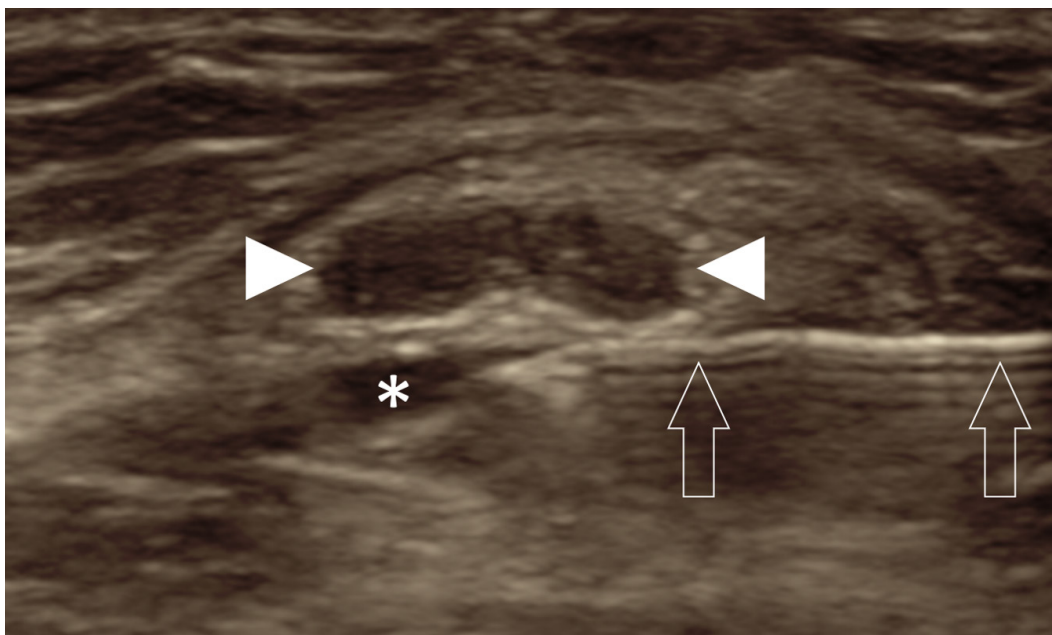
56-year-old male with a history of ulnar nerve transposition and persistent ulnar neuropathy. Ultrasound-guided injection of the transposed ulnar nerve at the level of the medial condyle. The needle (hollow arrows) is introduced with the tip adjacent to the epineurium, and injectate consisting of corticosteroid and local anesthetic is administered around the nerve (asterisk). The nerve (white arrowheads) demonstrates complete loss of normal fascicular morphology
